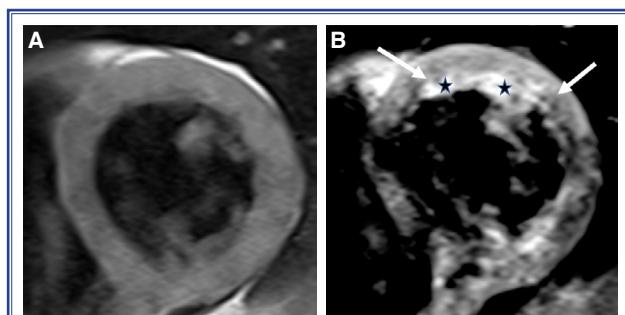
T1-weighted turbo spin echo (A) pre- and (B) post-contrast images of another patient with acute myocarditis. The signal increase depicted in the anterolateral wall of the left ventricle on post-contrast image (arrows) compared with pre-contrast image reflects hyperemia. Note: asterisks indicate blood pool enhancement, not myocardial hyperemia.
